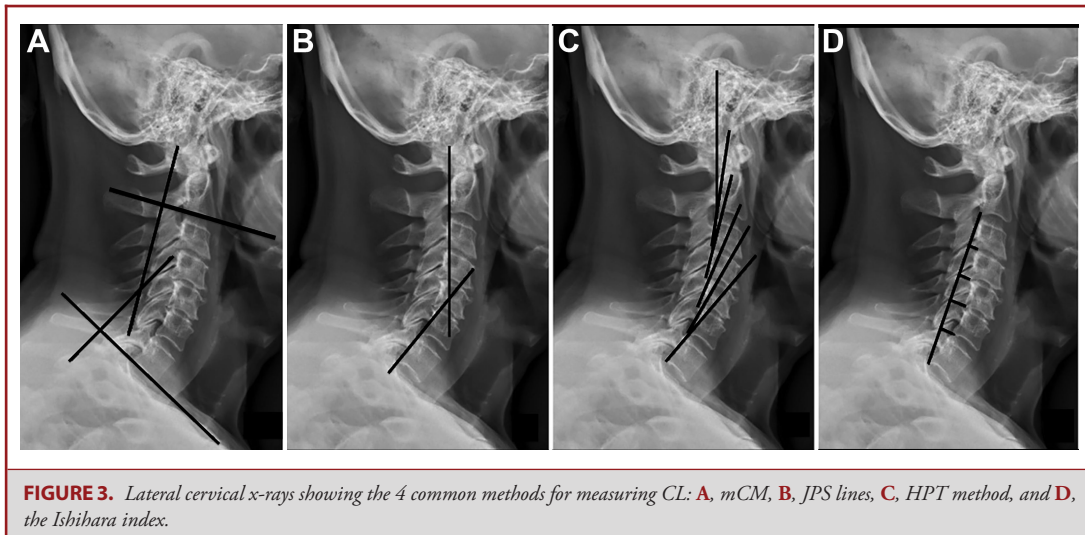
Lateral cervical x-rays showing the 4 common methods for measuring CL: A, mCM, B, JPS lines, C, HPT method, and D, the Ishihara index.
